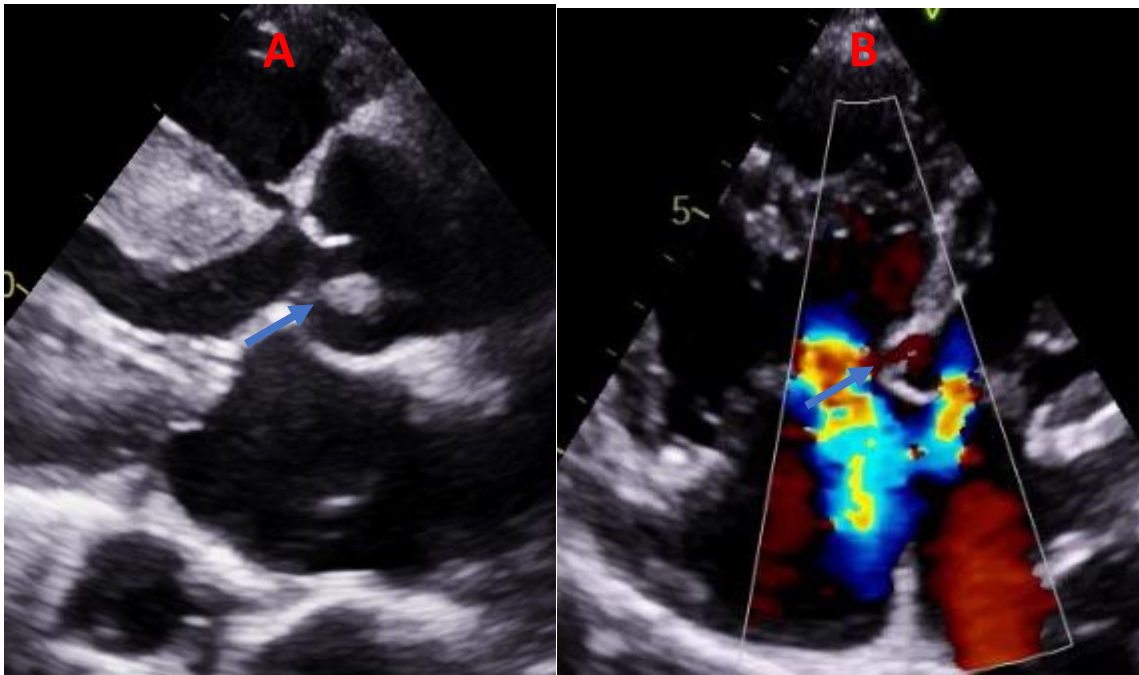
TTE: A- Long-axis parasternal view: shows a restrictive infundibular VSD with a left-to-right shunt of 3mm and echogenic formation on the posterior cusps of the aortic valve.
